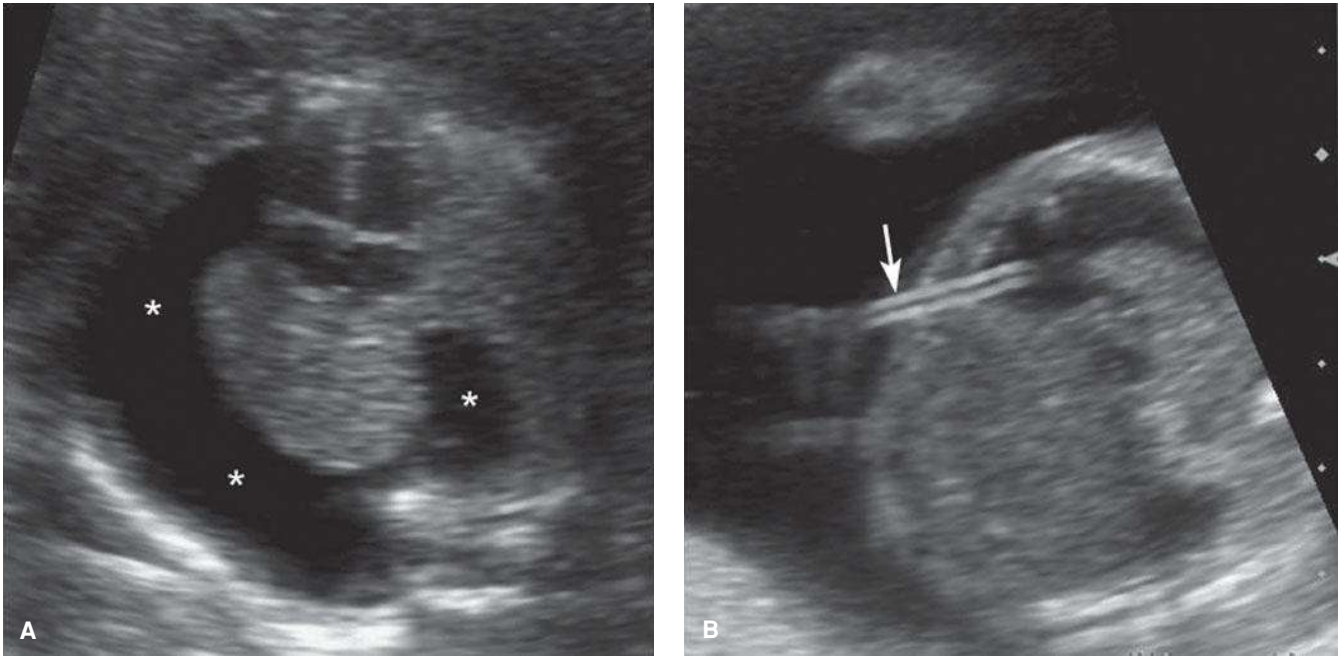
Thoraco-amnionic shunt placement. A. A large, right-sided fetal pleural effusion (*asterisks*) and ascites were identified at 18 weeks’ gestation. The effusion was drained but rapidly reaccumulated. The xanthochromic fluid contained 95-percent lymphocytes, consistent with chylothorax. B. A double-pigtail shunt (*arrow*) was inserted under ultrasound guidance. Following shunt placement, the effusion and ascites resolved.
